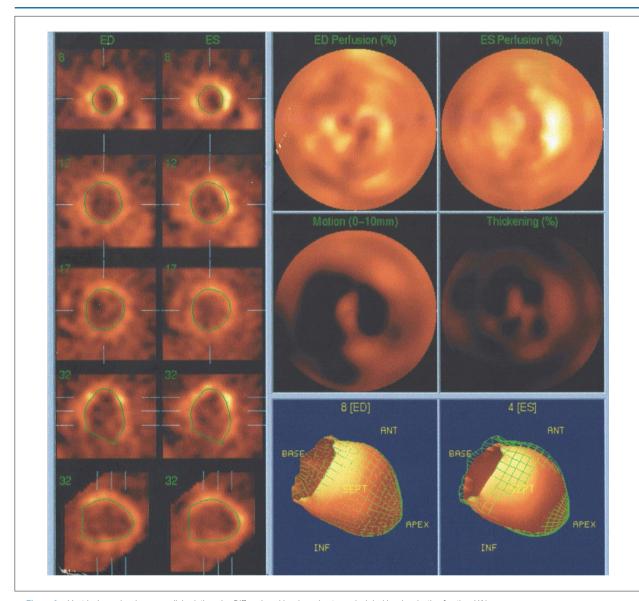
Ventriculography via myocardial scintigraphy. Diffuse hypokinesia and anteroapical dyskinesia, ejection fraction 11%.
